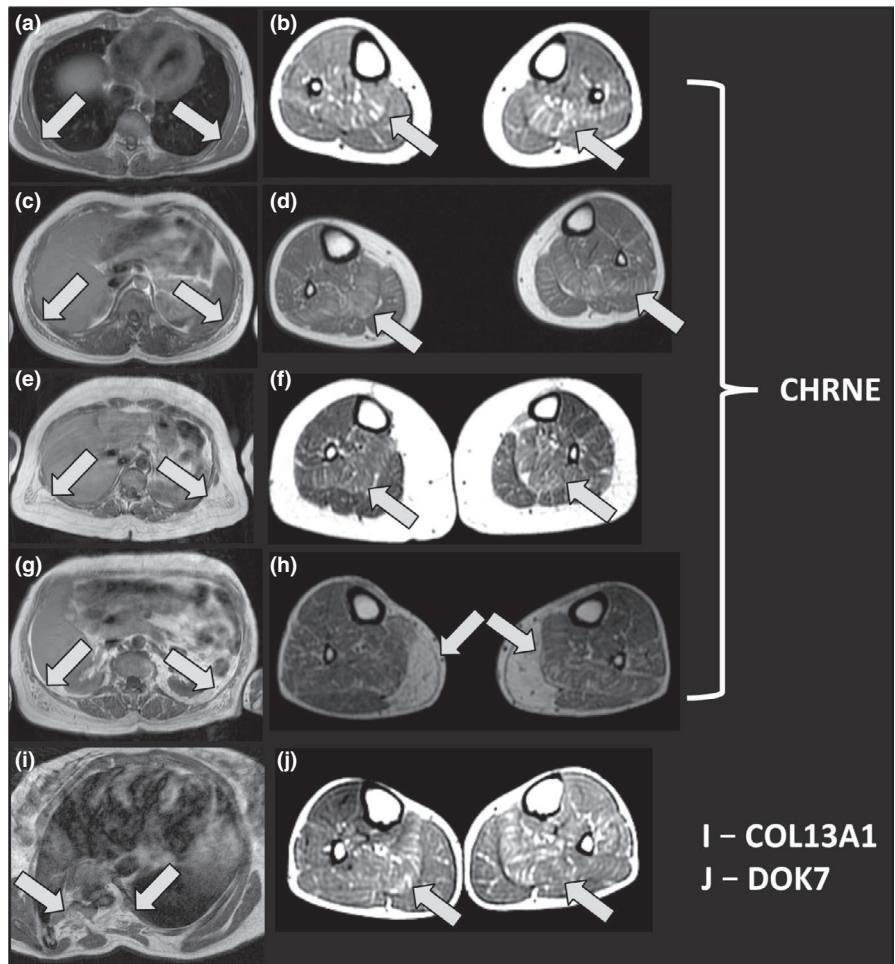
Magnetic resonance imaging (axial T1-weighted images) of six congenital myasthenic syndrome patients. (a), (c), (e) and (g) depict the latissimus dorsi muscle [arrows]: normal in (a), mild atrophy (grade 1) in (c) and severe atrophy (grade 3) in (e) and (g). (b), (d), (f), (h) and (j) show moderate atrophy (grade 2) of the soleus muscles [arrows in (b), (d), (f), (j)] and end-stage atrophy of the medial gastrocnemius [arrows in (h)]. (i) depicts severe atrophy (grade 3) of the paravertebral muscles (arrows) and deformity of the spine and thorax. (a) and (b) = patient 4, (c) and (d) = patient 17, (e) and (f) = patient 40, (g) and (h) = patient 39, (i) = patient 38, (j) = patient 47
